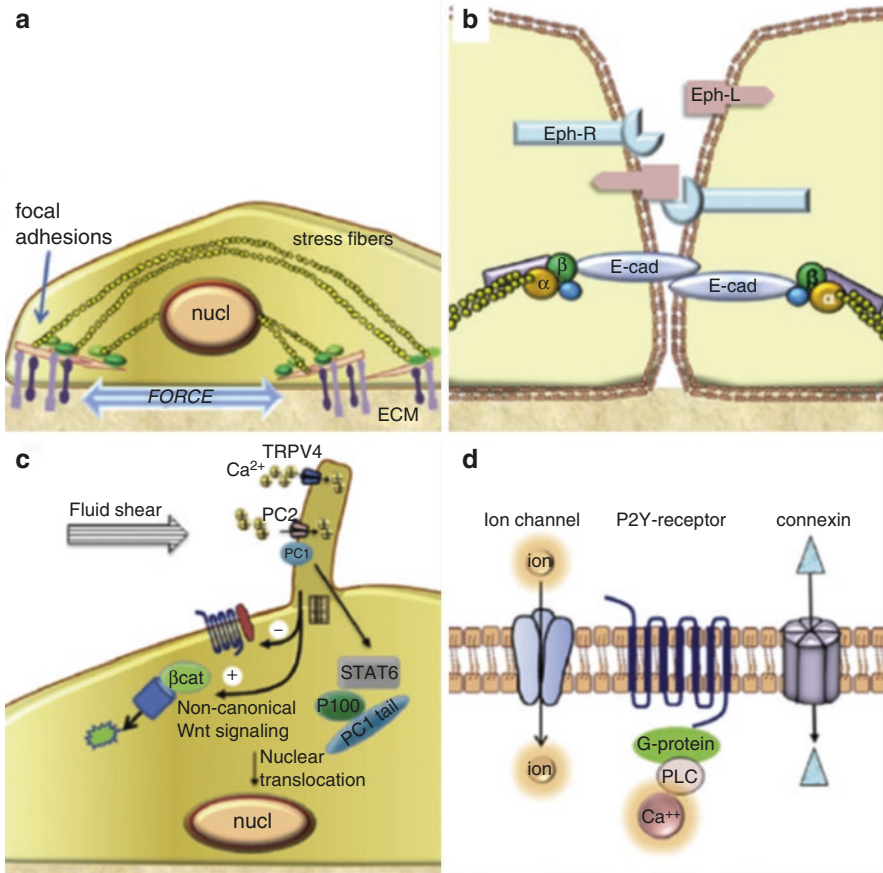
Candidate mechanotransducer systems. (a) Cell cytoskeleton senses loading at the membrane through integrins that transmit force through focal adhesions and F-actin stress fibers. (b) Cadherins, which connect to the cytoskeleton, are examples of outside-in signaling modifiers. Ephrins exemplify an intercellular signaling system regulated by movement of components within the plasma membrane. (c) Primary cilia may sense flow, pressure, and strain, activating ion flux through PC1 and TRPV4, which can activate Stat signals. Cilia also modulate Wnt signaling via noncanonical antagonism that leads to β -catenin degradation. (d) Membrane-spanning proteins such as ion channels, purinergic receptors, and connexins can be regulated through shear and strain. Used with permission from Thompson WR, Rubin CT, Rubin J. Mechanical regulation of signaling pathways in bone. *Gene*. 2012;503:179–93
